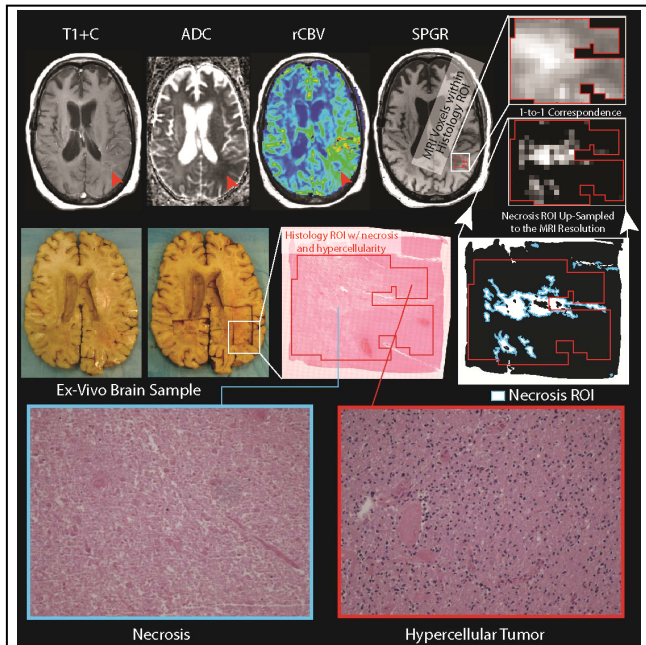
MRI versus ex-vivo sample location. A region of interest was created highlighting the radiation necrosis and was then up-sampled to the MRI resolution for 1-to-1 comparison. ADC and rCBV values from this ROI were compared to surrounding hypercellularity and a region of normal WM.
